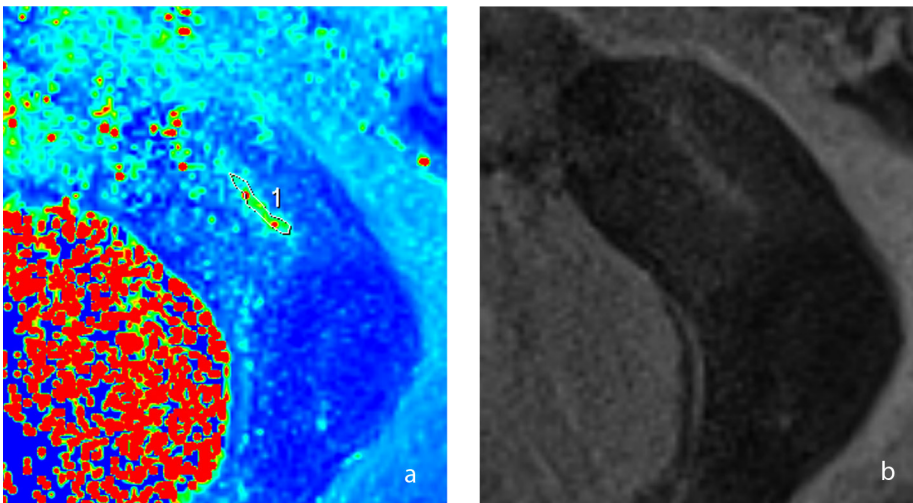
The ROI of normal endometrium in one slice in a 70-year-old volunteer. (a) T2 map of normal endometrium "1" was the ROI. (b) T2-weighted image was used as the reference image. ROI, region of interest.
